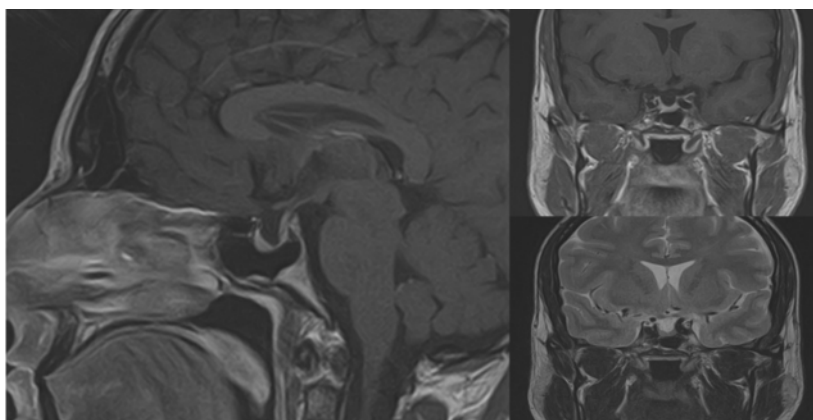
Pituitary MRI showing partial empty sella.
